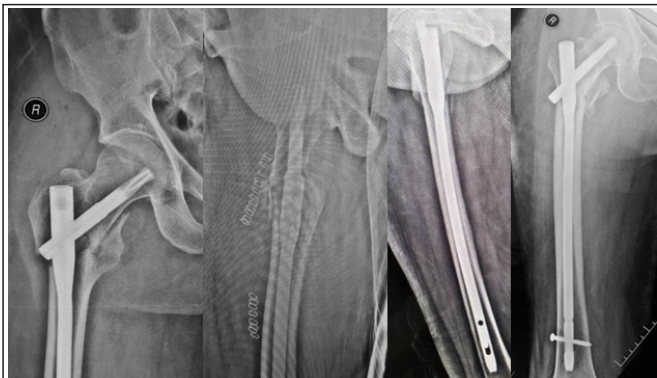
Immediate post-operative radiographs in AP and lateral views followed by 6 months post-operative AP and lateral views.
